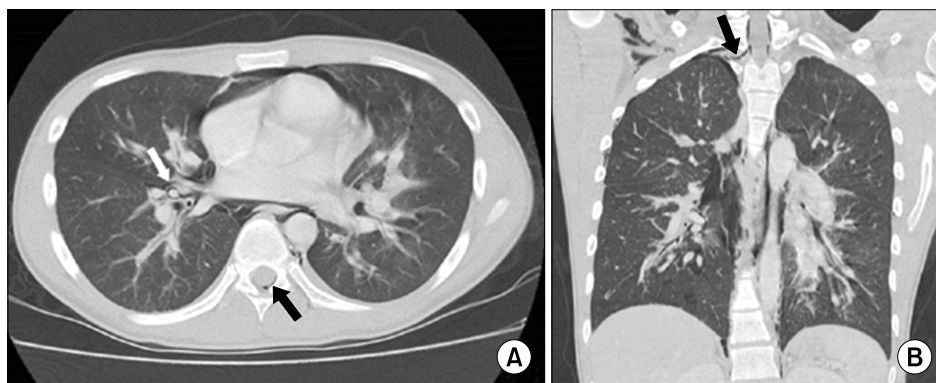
Computed tomography of the chest confirming pneumomediastinum with concurrent pneumorrhachis. (A) Computed tomography of the chest demonstrating air dissection along the bronchovascular sheath (white arrow) and the presence of air in the dorsum of the spinal canal (black arrow). (B) Coronal view of the computed tomography image showing air entering the spinal canal through the neural foramen (arrow) combined with right pneumothorax and subcutaneous emphysema.
